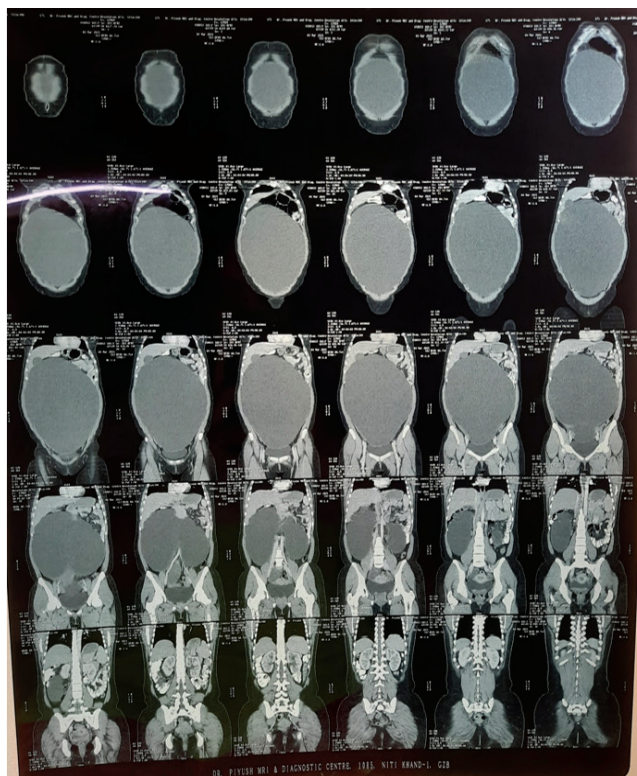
Contrast Enhanced Computed Tomographic Scan of Abdomen and Pelvis revealing a large hypodense lesion within the mesentery almost occupying the entire abdominal cavity
